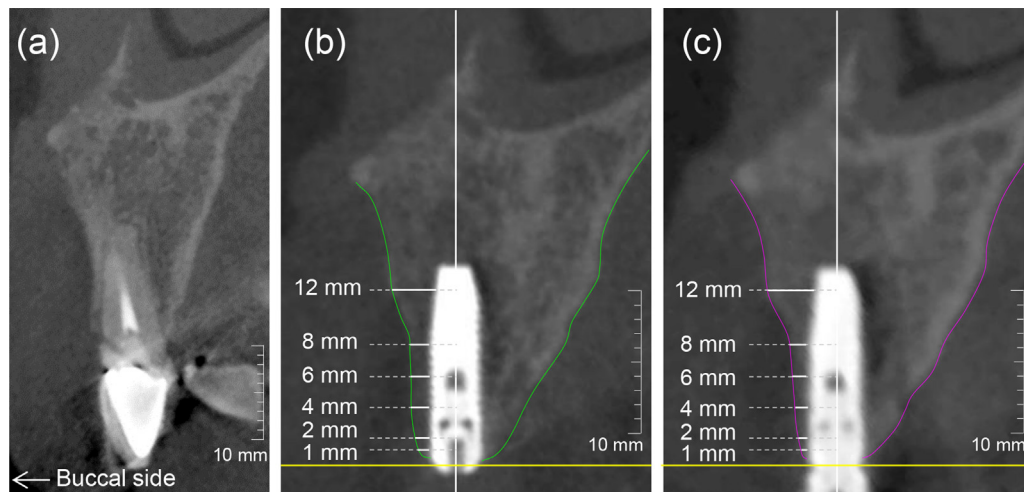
2D sectional images of CBCT.
